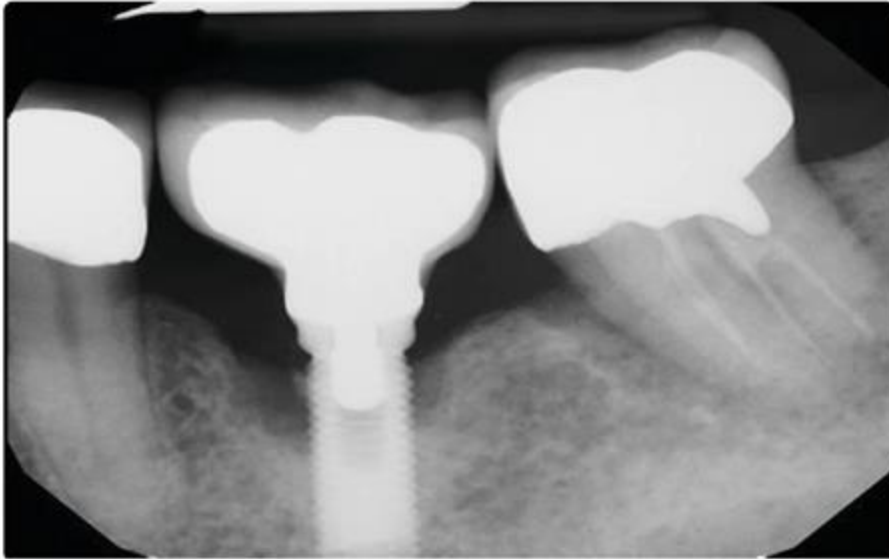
X-ray shows retained cement on mesial of implant. Photo courtesy of M. Virginia Kirkland, DMD, MS.
